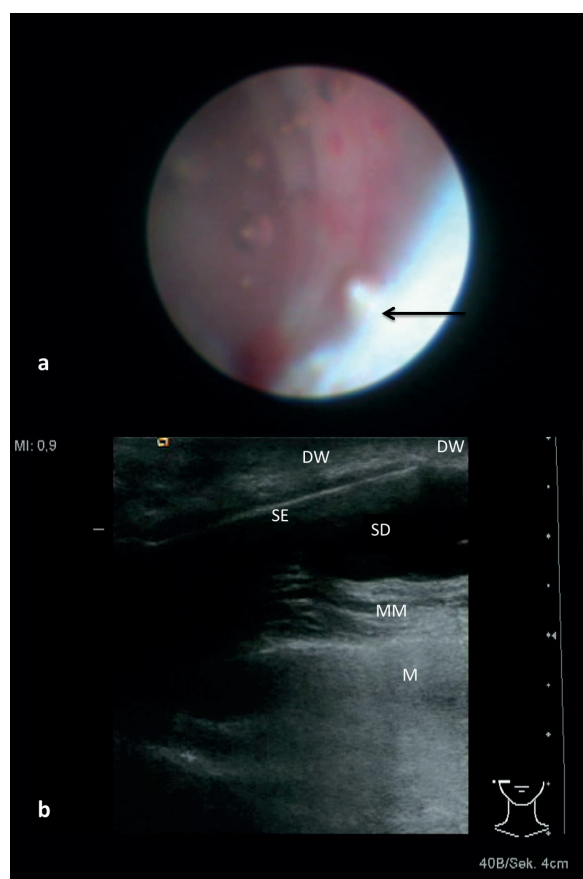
A, Sialendoscopic view to a complete stenosis (middle parotid duct): the micro-drill (*green arrow*) is positioned in front of the suspected residual lumen within the area of the stenosis (*black arrow*). B, Ultrasound shows the micro-drill emerging out of the working channel at the tip of the sialendoscope (*green arrow*) and positioned within the duct wall (false passage with the sialendoscope). Abbreviations: SD, Stensen's duct; DW, duct wall; M, mandible; MM, masseter muscle; SE, sialendoscope.
